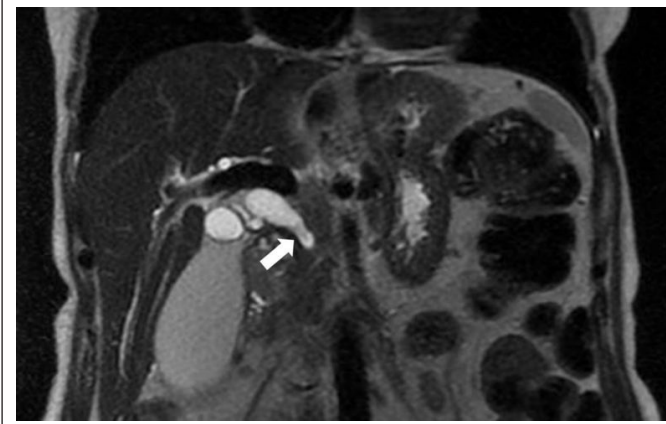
In the coronal T2-weighted magnetic resonance image of a 60-year-old female patient with hyperbilirubinemia, a hypointense lesion (arrow) is observed distal to the common bile duct (CBD), accompanied by dilation of the proximal bile ducts
